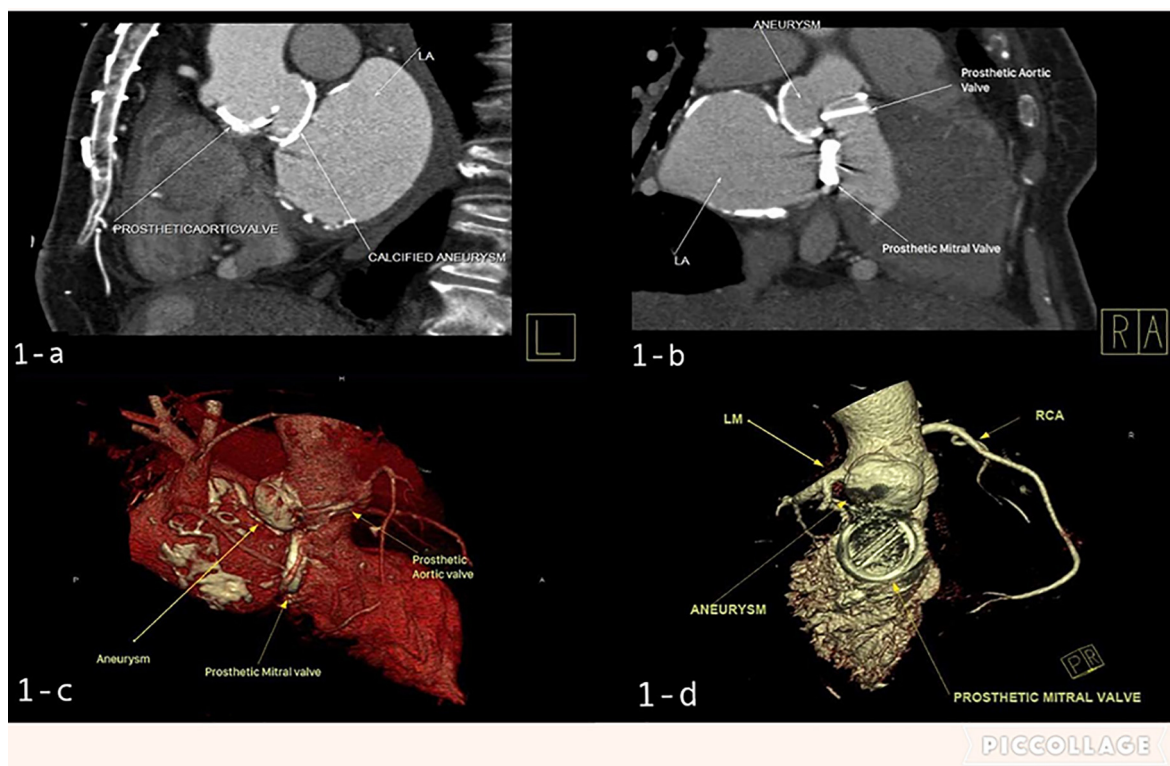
Computed tomography scan reconstructions showing aneurysm formation of pericardial patch. (A) Left sagittal; (B) right sagittal; (C) right three dimensional; (D) posterior three dimensional. LA, left atrium; LM, left main; RCA, right coronary artery.
